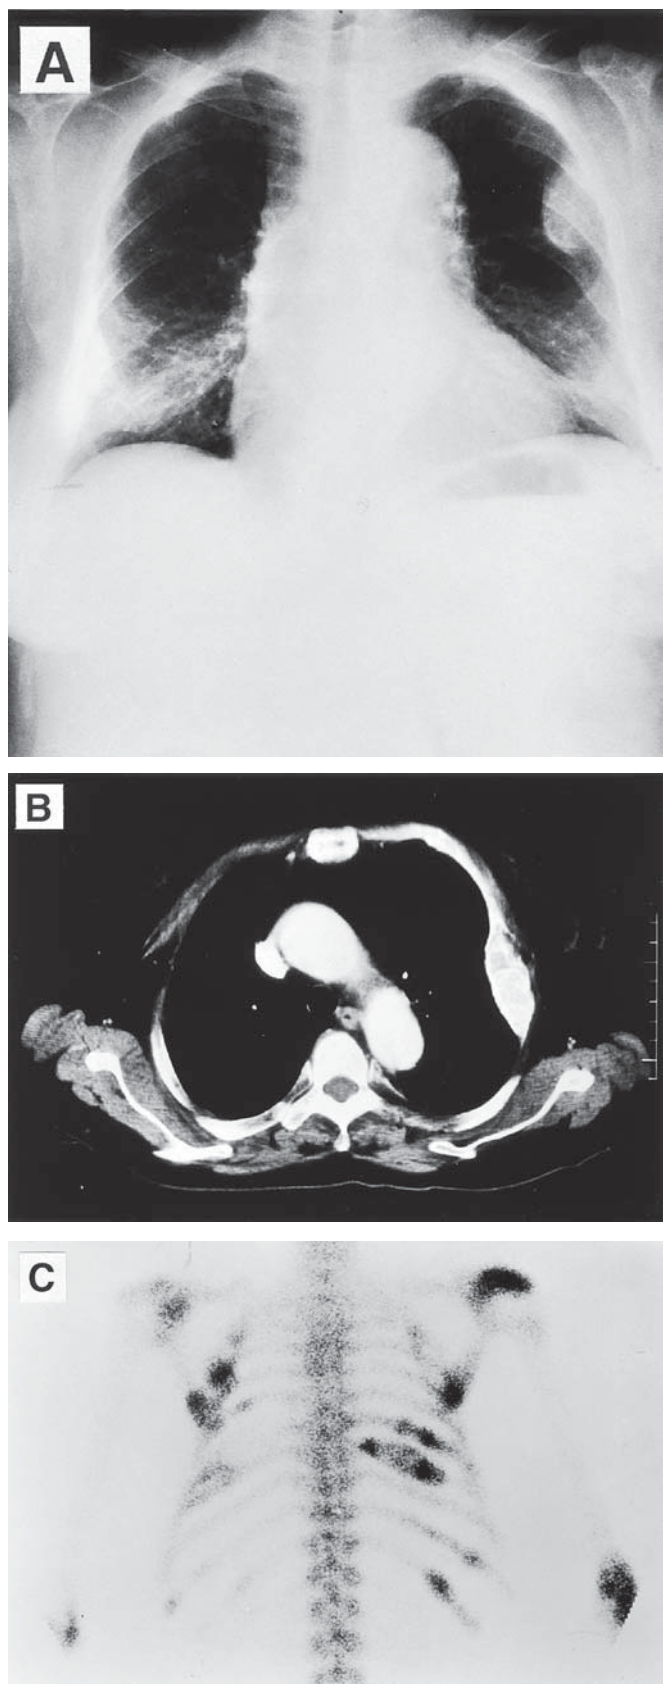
(A) Chest radiograph showing multiple tumor-like shadows in the chest wall. (B) Computed tomographic scan of the chest demonstrating an intramedullary mass in the left rib. (C) Bone scan demonstrating increased uptake in multiple areas of the ribs.
